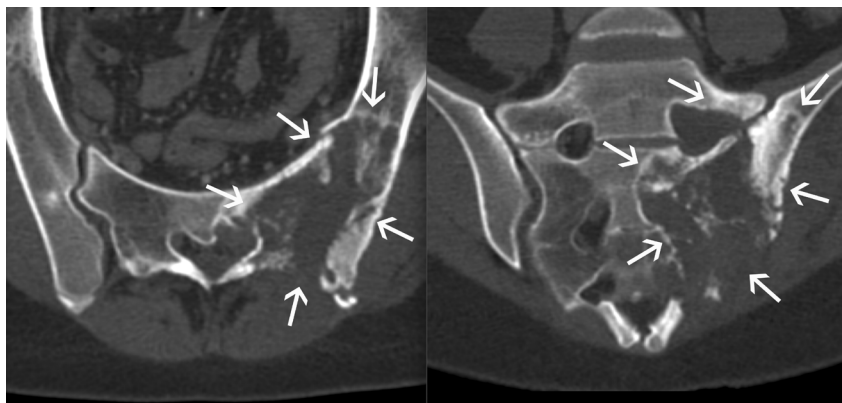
Axial and coronal CT images of a 16-year-old girl with Ewing sarcoma of the sacrum displaying a large aggressive lesion (straight arrows) with a wide zone of transition centered in the left sacral ala, causing marked osteolysis, crossing the sacroiliac joint, and resulting in osseous destruction of the adjacent ilium.
